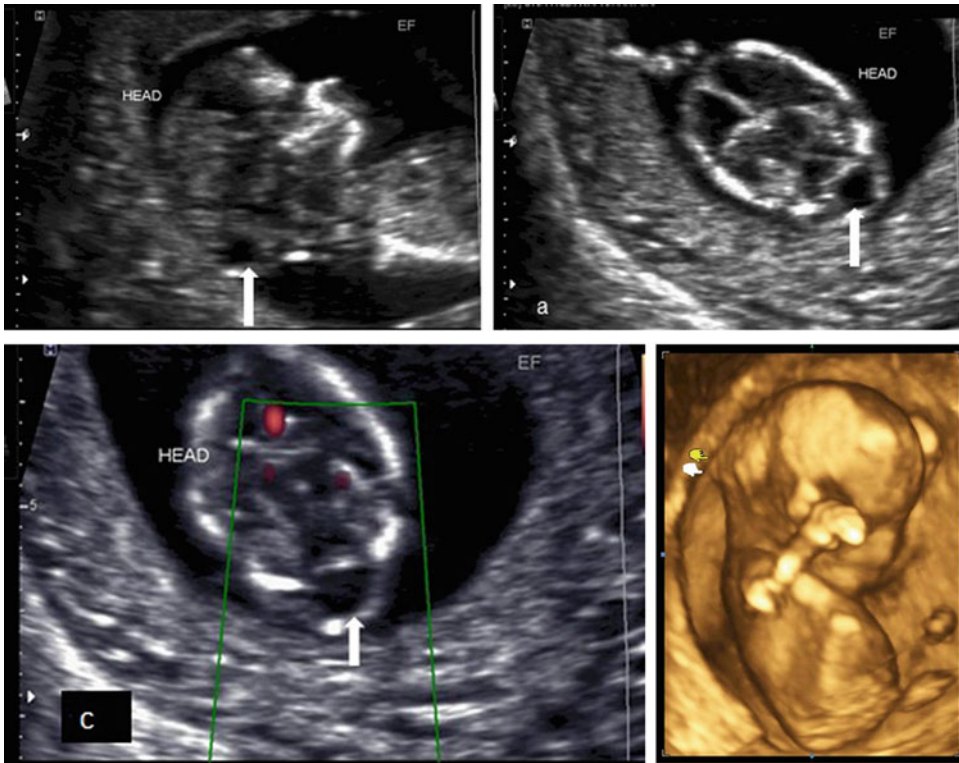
14 week GA fetus US with midline occipital encephalocele (*white arrows*) defined on (a) axial US. (b) sagittal US and (c) axial US with color Doppler. No flow
